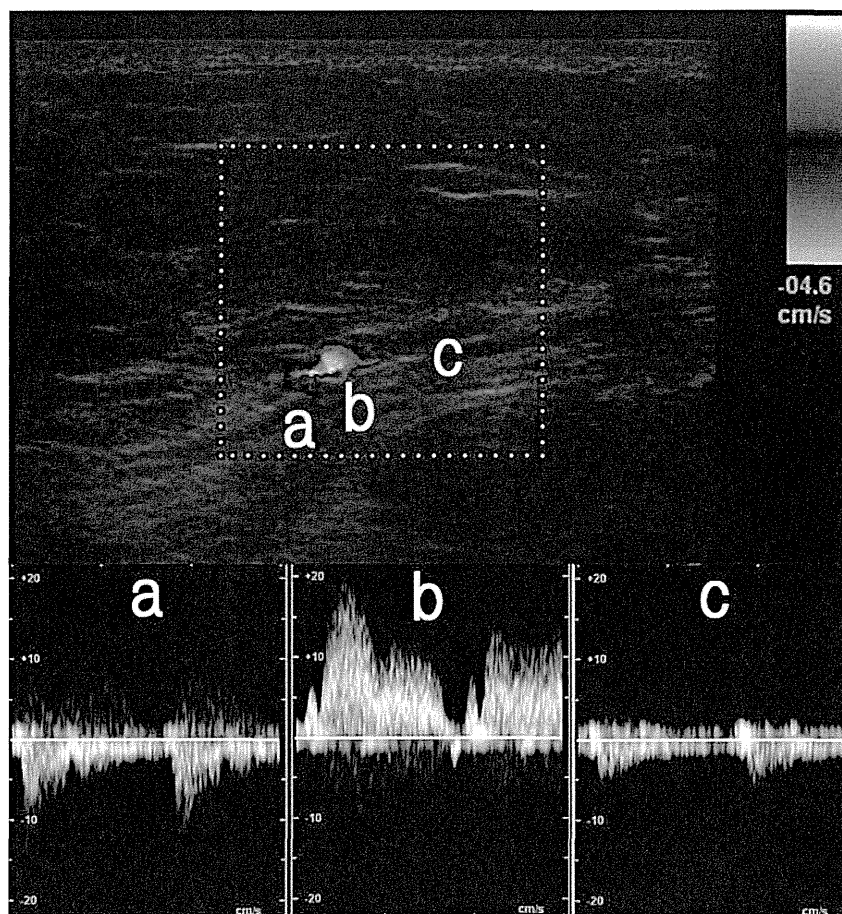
Doppler spectrum of the DIEA (b) and DIEVs (a and c) in patient 2 six months postoperatively. DIEV1 (a) was anastomosed to the antegrade IMV and DIEV2 (c) was anastomosed to the retrograde IMV. The wave pattern shows that the direction of flow of the DIEVs (a and c) and DIEA (b) are opposite. The flow velocity of the DIEV2 (c) anastomosed to the retrograde IMV is lower than that of the DIEV1 (a) anastomosed to the antegrade IMV.
